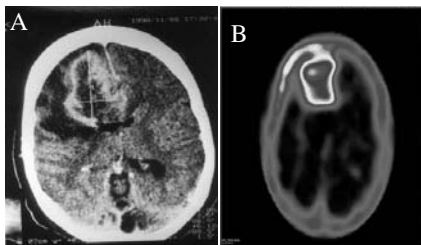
A. Coronal section of frontal glioblastoma multiforme showing contrast enhancement in CT. B. Corresponding SPECT slice of the same patient showing avid ^{99m}Tc - G H A concentration
